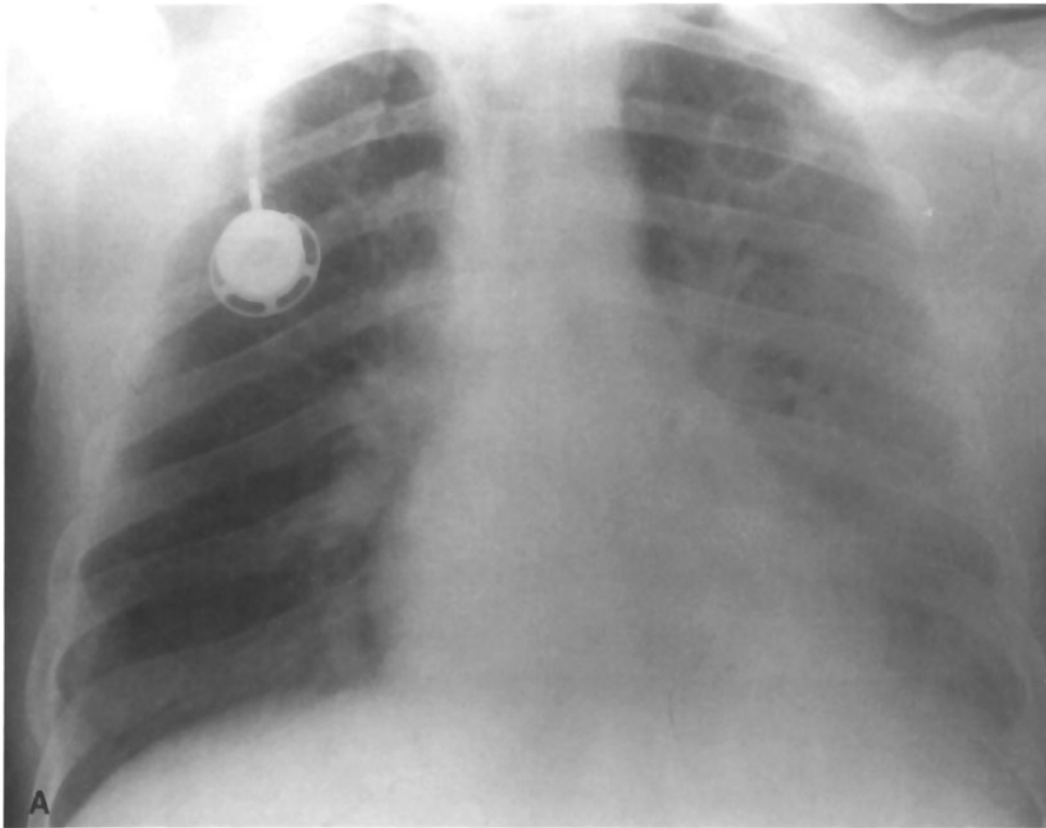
(A) Chest radiograph of a 38-year-old man with AIDS who presented with fever, cough, and malaise of 3 weeks' duration. His CD4⁺-lymphocyte count was 87 at the time of admission. An abscess cavity was seen in the left upper lobe. Bronchoscopic biopsy revealed only *P. carinii*. (B) Chest radiograph of a 43-year-old woman who became febrile and dyspneic 6 weeks following liver transplantation. A small abscess cavity was seen (↔) in addition to a benign right-sided pleural effusion. Percutaneous needle aspiration of the abscess cavity revealed *P. carinii*. (C) A CT scan of the chest demonstrates progression of the abscess despite therapy with intravenous pentamidine. The patient recovered completely after 4 weeks of therapy.
